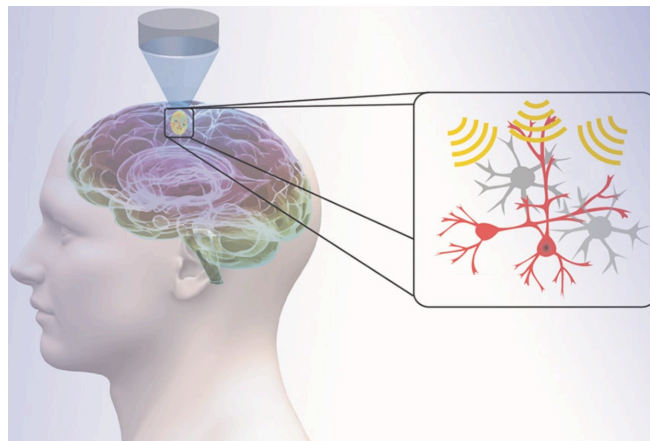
Transcranial Focused Ultrasound (tFUS) for wireless neuromodulation⁷⁸
